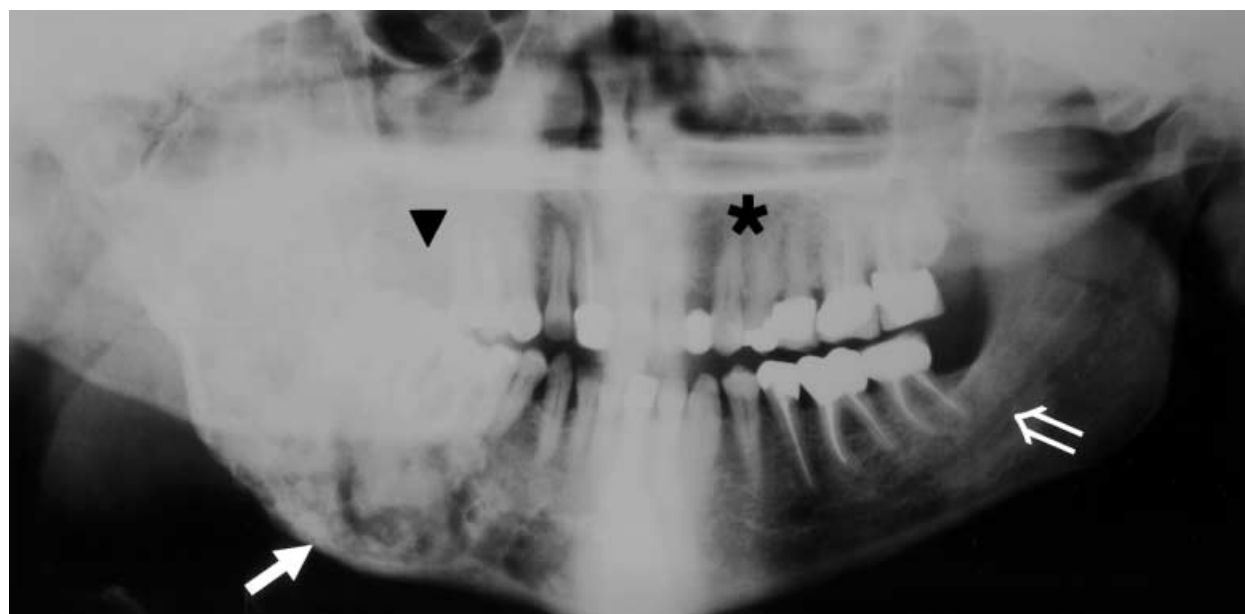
Mixed radiolucent/radiopaque pattern. Fibrous dysplasia (FD) of maxilla and mandible in a 53-year-old female patient. Panoramic radiograph demonstrated mixed radiolucent/radiopaque (mixed density) pattern of right mandibular FD lesion (solid white arrow) and masking of the outline of right mandibular canal compared with visible mandibular canal outline (open white arrow) of unaffected left body of mandible. Bilateral maxillary FD is radiopaque on right (triangle) and ground glass on the left (star). Endocrinopathies in this patient included hyperthyroidism and hypercortisolism as well as renal phosphate wasting
